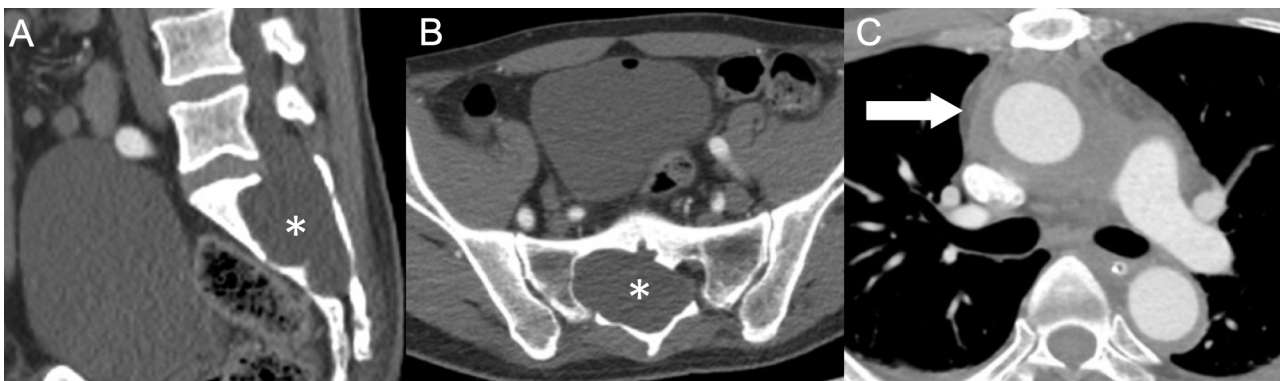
Computed tomography (CT) aortogram showed dural ectasia (*in A and B) and intramural haematoma of the ascending aorta (arrow in C).
